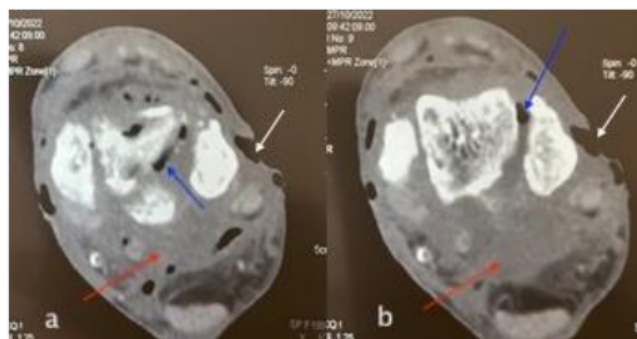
Axial ankle CT scan showing diffuse infiltration of the soft tissues (red arrows) with significant gas extending from subcutaneous soft tissues and penetrating between bone structures (blue arrows). Note loss of cutaneous substance (white arrows).
